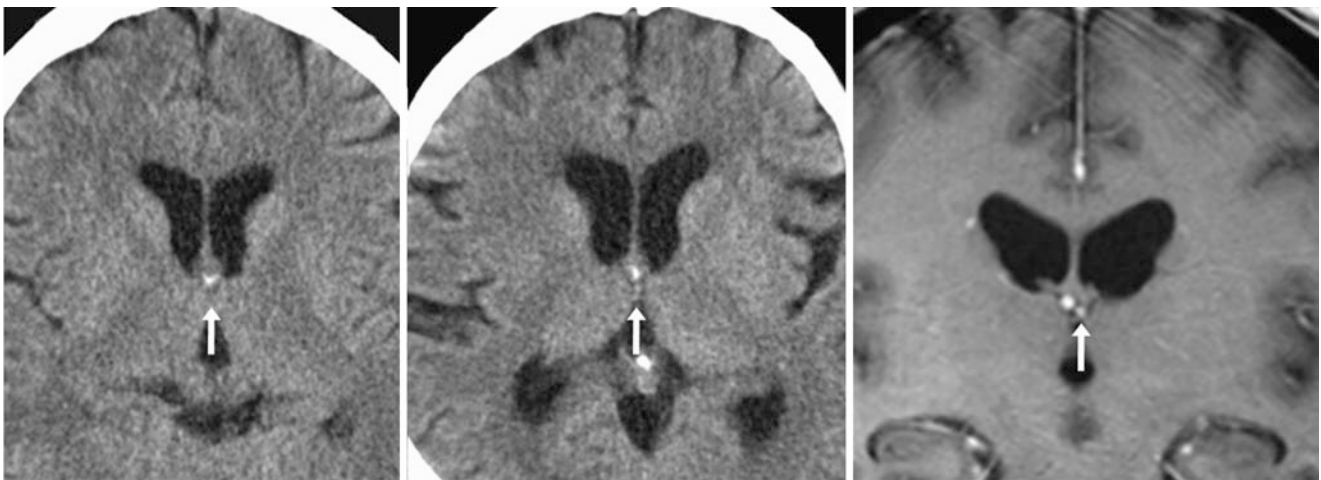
A 62-year-old with a partially calcified lesion (arrows) on NECT (left) within the anterior third ventricle that did not change 9 months later (middle). On a 3 T MRI that included postcontrast coronal T1WI (right), this was found to be a CP that moderately enhanced with contrast
